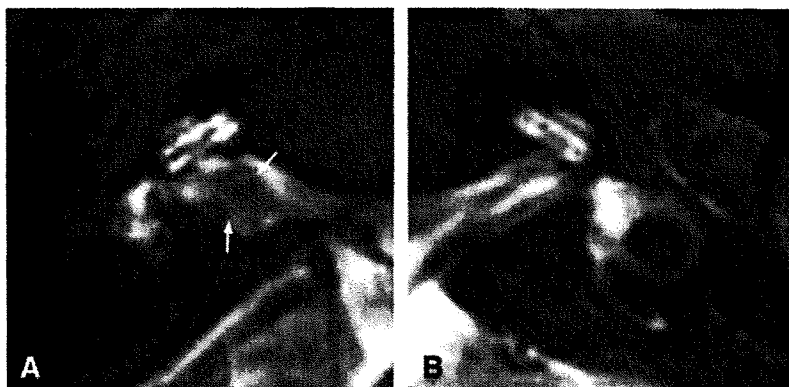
Heavily T2-weighted 3D constructive interference in the steady-state imaging of case 1. A, right ear; B, left ear. In these heavily T2-weighted images, both the endolymph and the perilymph are white and no differences were detected between the right and left ears. The remaining acoustic tumor of the right ear is indicated by arrows.
